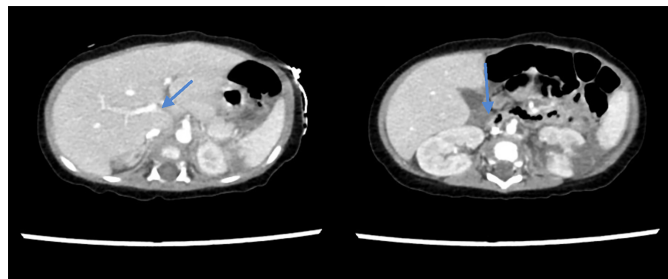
CT images showing multiple aneurysms of large and medium-sized vessels, i.e., coeliac and superior mesenteric artery (blue arrows).
